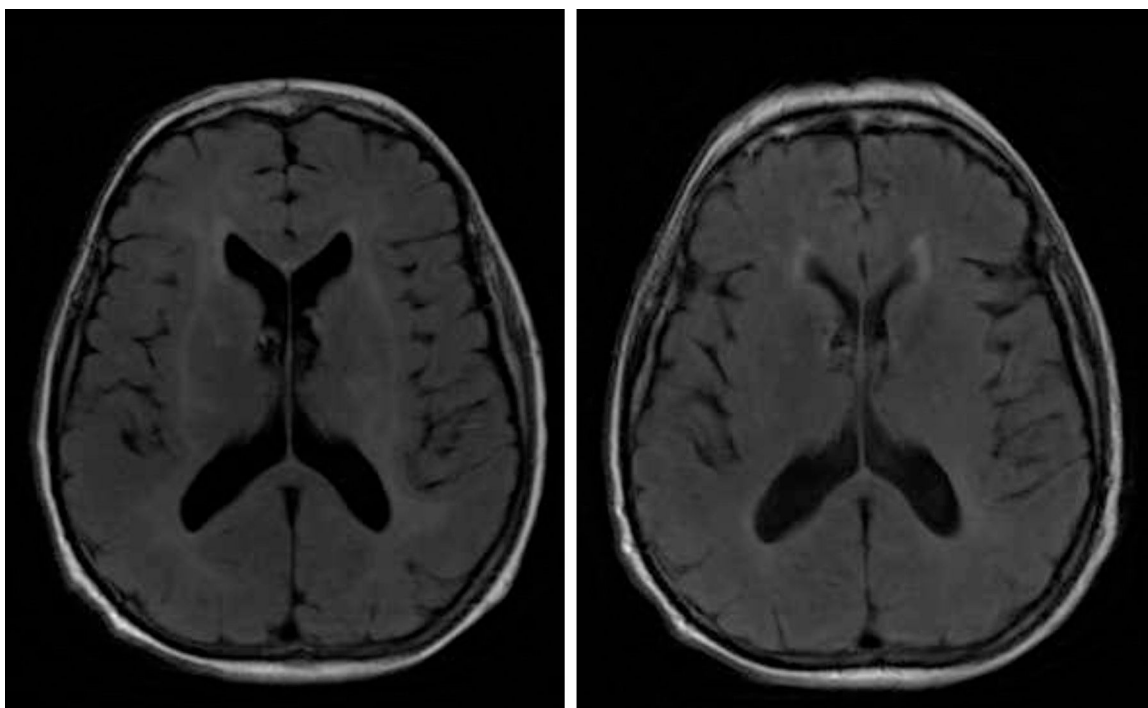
Brain MRI. T2-weighted FLAIR sequence. A) Baseline: bilateral diffuse involvement of the white matter, except for the U-shaped fibres. B) Three months after tumour resection: decreased leukoencephalopathy (barely visible).
